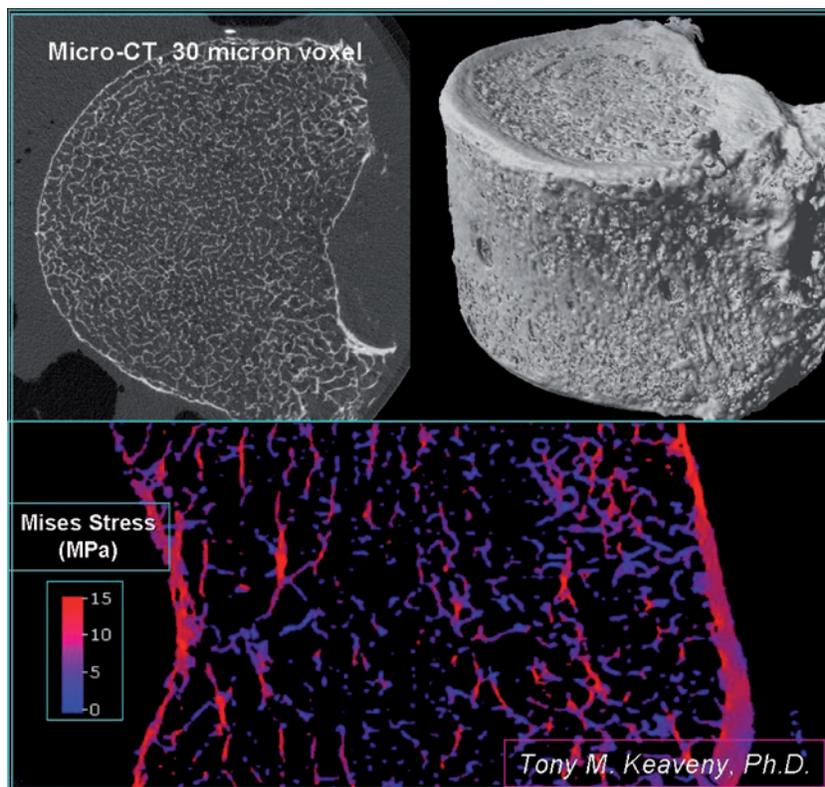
Micro CT of vertebral body at 30- μm resolution and generation of micro finite-element model at the trabecular level. Courtesy of Tony Keaveny. (See plate section)
